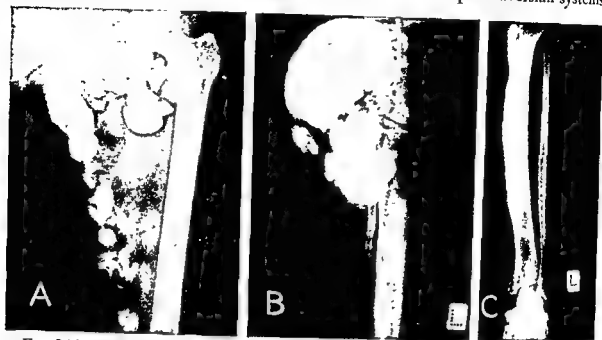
Roentgenographic appearance of a most unusual case with marked involvement of soft tissue by dense masses which were excised and proved to be osteochondromas. A demonstrates the extensive deposits in the soft parts of the upper thigh. B, Appearance of the mass about the knee. C, Note the changes in the tibia strongly suggestive of melorheostosis. A unique case which was first regarded as an example of tumoral calcinosis.
